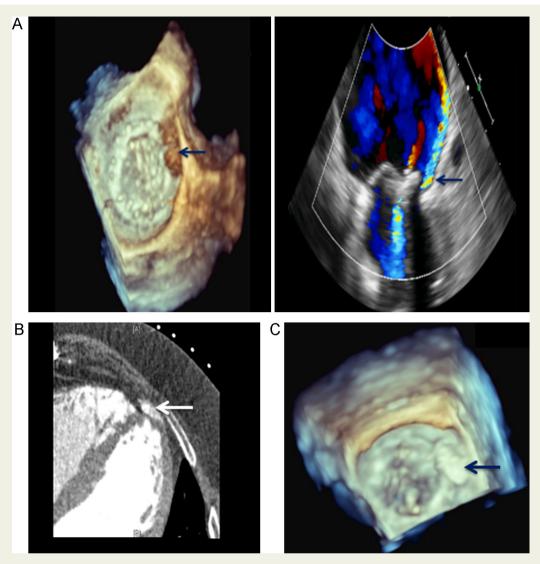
A 2D and 3D trans-oesophageal echocardiogram (TEE) showing moderate to severe mitral regurgitation due to a large crescentic shaped lateral para-valvular defect (arrow).
